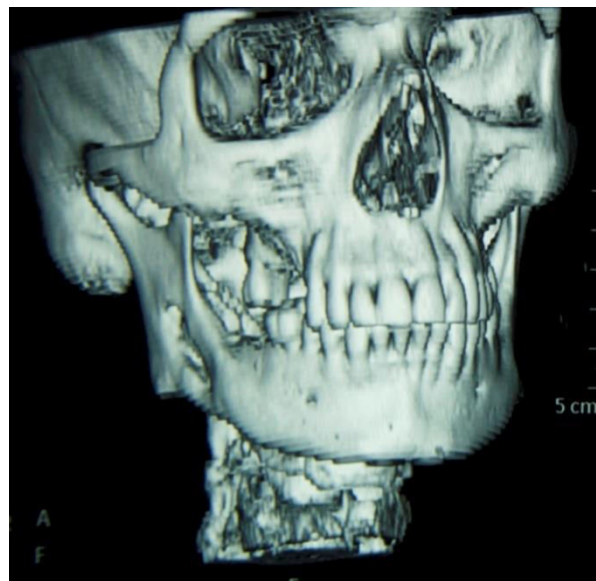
Computed Tomography (CT) scan
